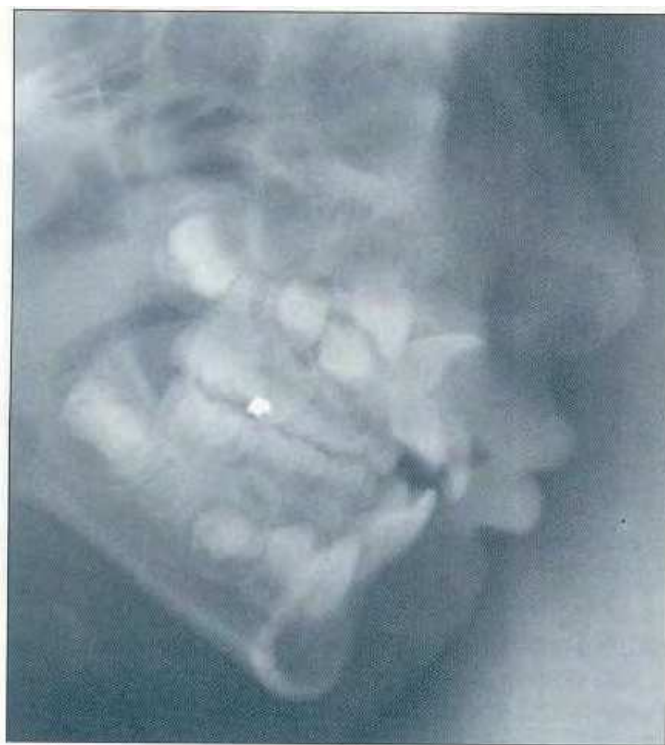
the direction of the crown and the angle of the root are well highlighted in this lateral cephalometric radiograph.
